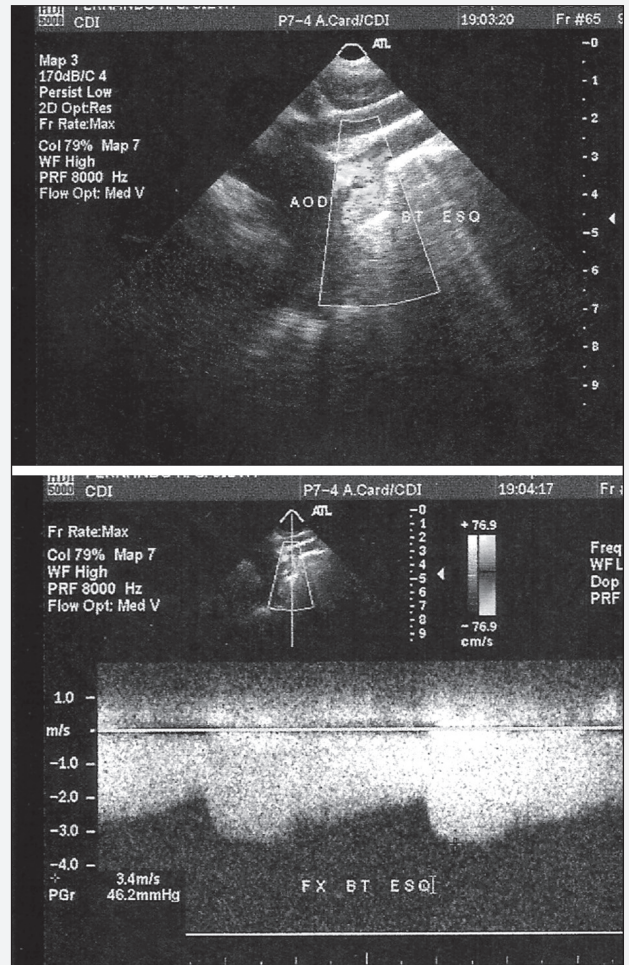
Echocardiographic image during late postoperative period on continuous color Doppler, flow by the Blalock Taussig.
